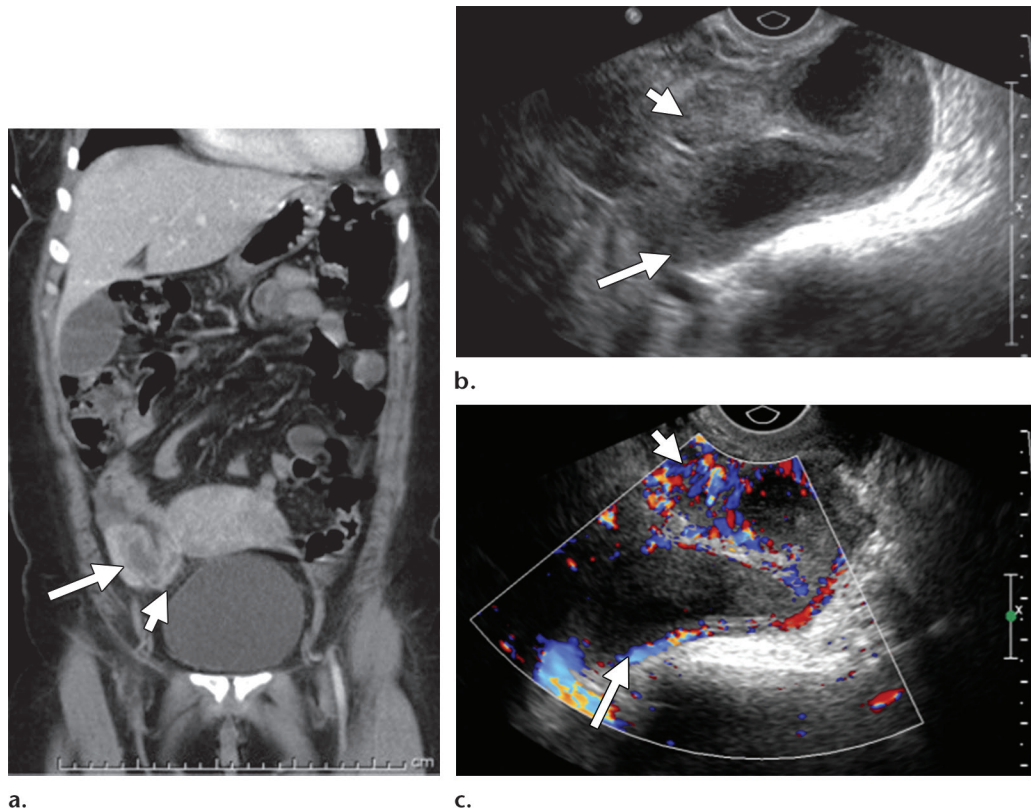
Pyosalpinx in a 48-year-old woman presenting with fever, right lower quadrant abdominal pain, and leukocytosis. (a) Coronal contrast-enhanced CT image shows a dilated right fallopian tube with a thick enhancing wall (long arrow) and peritubal fat stranding (short arrow), findings compatible with pyosalpinx. No frank tubo-ovarian abscess was depicted. (b, c) Corresponding transvaginal gray-scale (b) and color (c) US images show a dilated thick-walled right fallopian tube (long arrow) containing hyperechoic material, with surrounding hyperemia, findings compatible with pyosalpinx. Note the closely adherent hyperemic but small ovary (short arrow), which demonstrates an otherwise unremarkable parenchyma.
